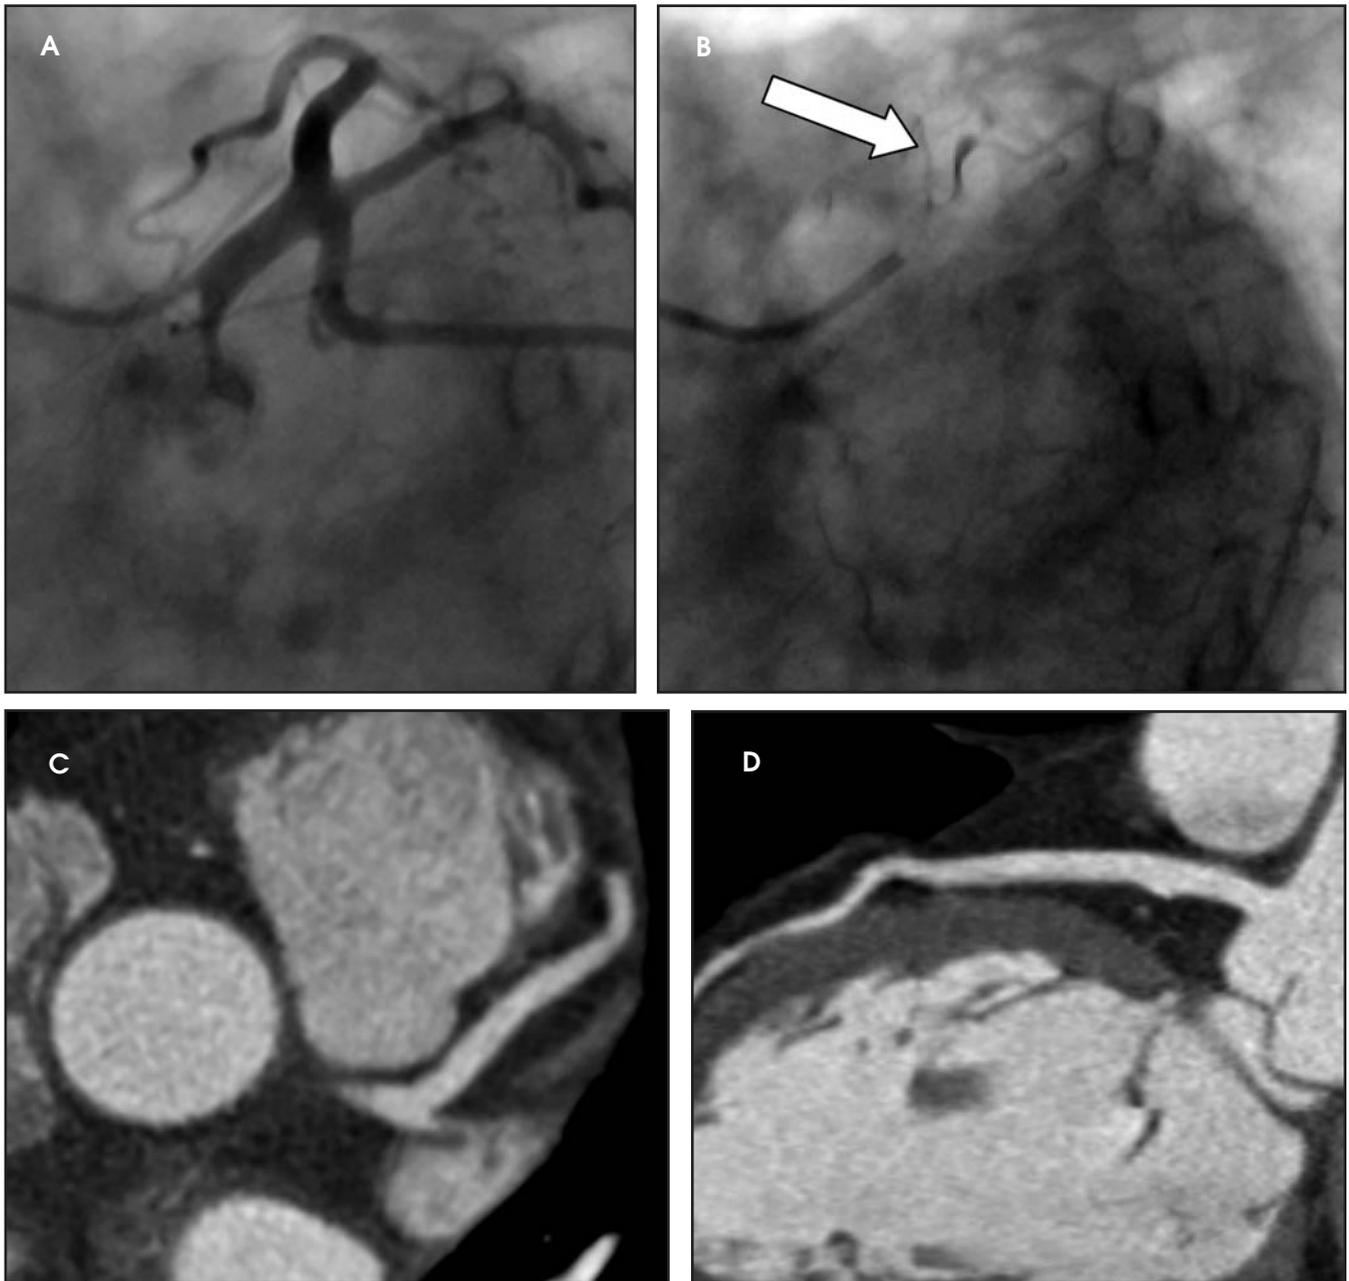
A 54-year-old patient was suspected of having a dissection of the proximal left anterior descending coronary artery, (A and B) which was suggested by the persistence of a small amount of contrast material (arrow) after each injection. (C and D) Coronary CT angiography shows that the proximal left anterior descending coronary artery is completely normal, suggesting that the persistence of contrast material was the result of a flow phenomenon.
